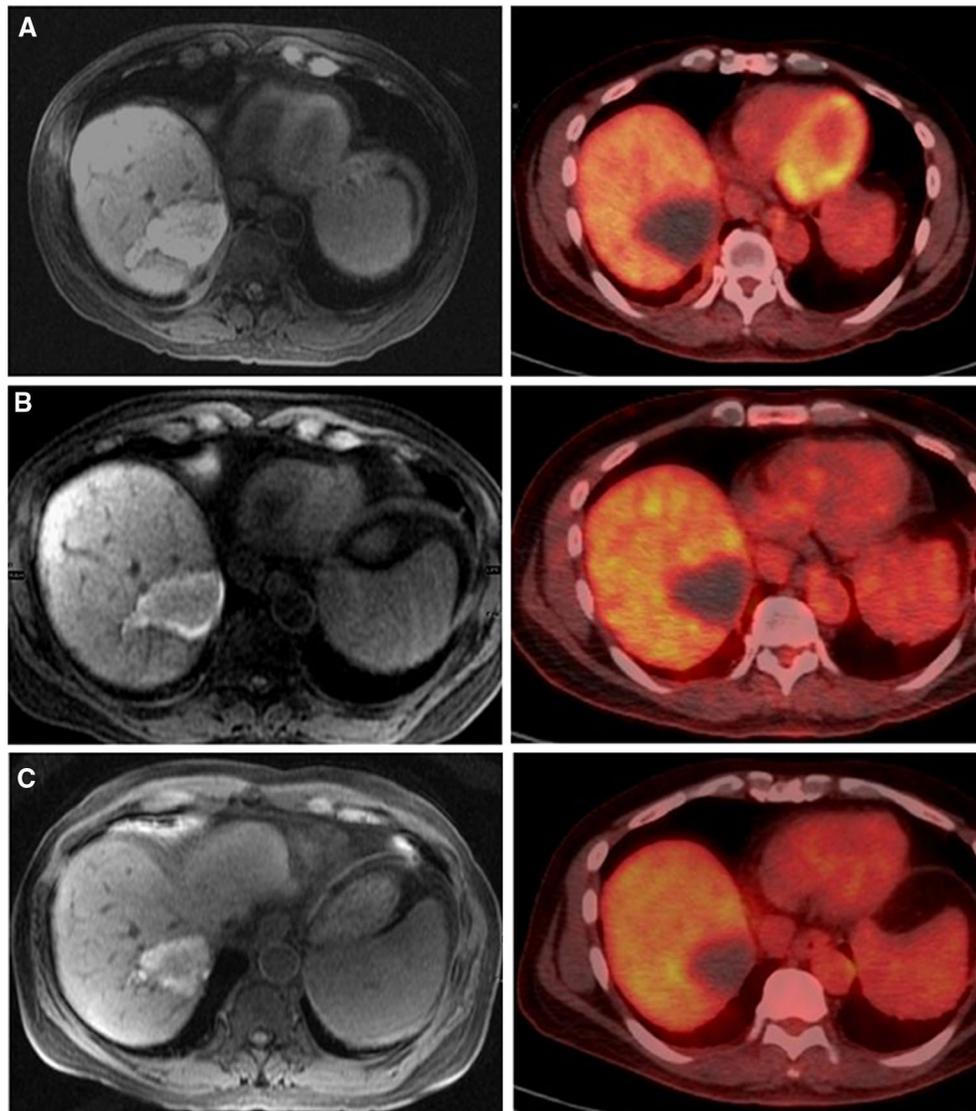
Follow-up MR (*left panel*) and PET CT (*right panel*) at 3 months (A), 6 months (B), and 30 months—latest imaging (C)
